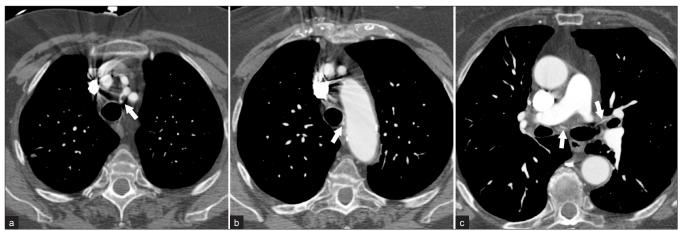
Contrast-enhanced axial CT images of the chest. (a) A common trunk anomalous bronchial artery arises from the left vertebral artery. (b) This bronchial artery courses inferiorly along the trachea. (c) Bifurcation of the bronchial artery into left and right branches, which supply the respective lungs.
